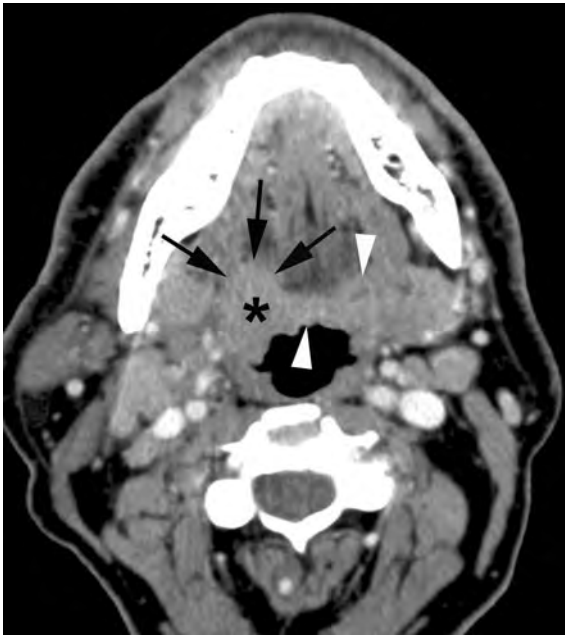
Axial contrast-enhanced CT-image in a patient with a right-sided tongue base cancer (*asterisk*). The lesion shows the same density as the lingual tonsil (*arrowheads*), but can be identified because it infiltrates the deeper tissues of the tongue base (*arrows*, compare to opposite side)
